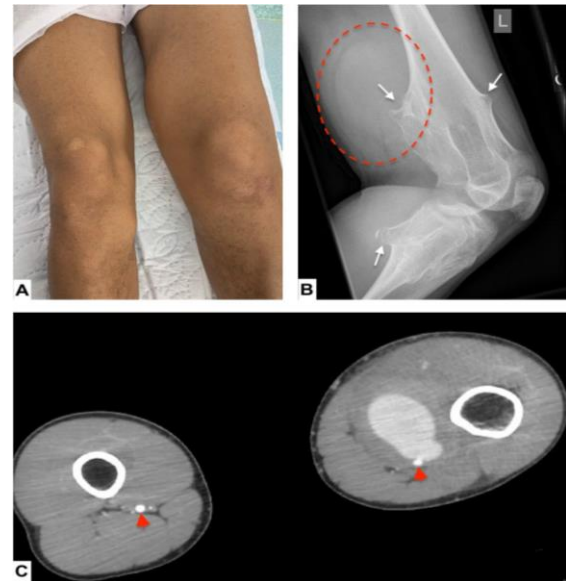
A) Preoperative image demonstrating a deformed left lower extremity with medial swelling and palpable mass. B) Lateral knee X-ray (image limited due to the patient's decreased range of motion) shows several exostoses involving the proximal tibia and fibula as well as the distal femur (white arrows). Adjacent to a supracondylar exostosis, there is a large soft tissue mass surrounded by a fine hypodense line (dotted oval). C) Axial CTA of the lower extremities demonstrating a large pseudoaneurysm homogeneously filled with contrast on the anterior surface of the distal left SFA (red arrow).
